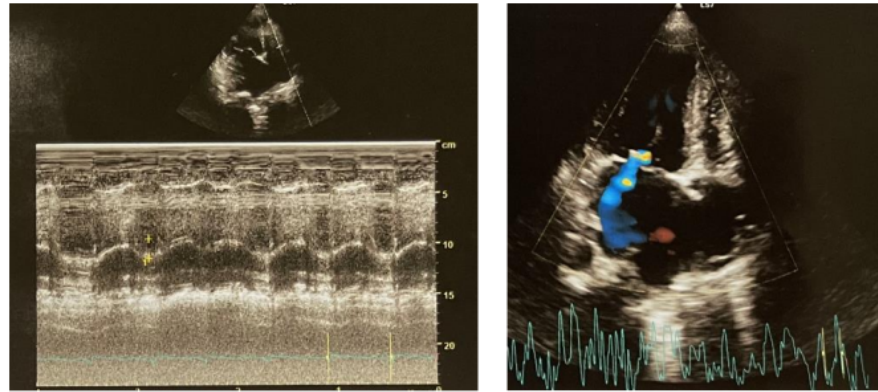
Echocardiography: MS Severe, MR Severe, TR Moderate, Moderate Probability of PH.
